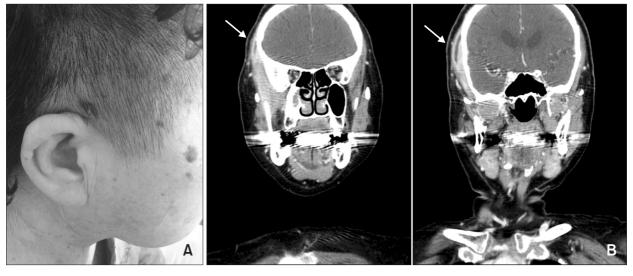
The drainage scar is formed on the preauricular incision site. (A) The patient's symptoms had subsided, and swelling disappeared on the right temporal muscle region at 26 days postoperation. (B) A follow-up computed tomography scan 26 days after surgery showed significant decrease of abscess in the subgaleal space (arrows) along the temporalis muscle.
